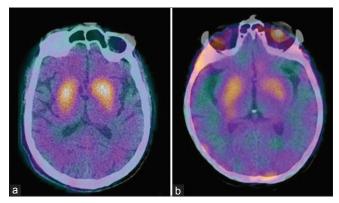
Single-photon emission computed tomography/computed tomography tranxial image (a) of 70-year-old healthy volunteer showing bilaterally symmetrical comma-shaped normal uptake in striatum, (b) of a 68-year-old patient diagnosed to have idiopathic Parkinson's disease with predominant right-sided symptoms showing reduced tracer uptake in the left putamen
